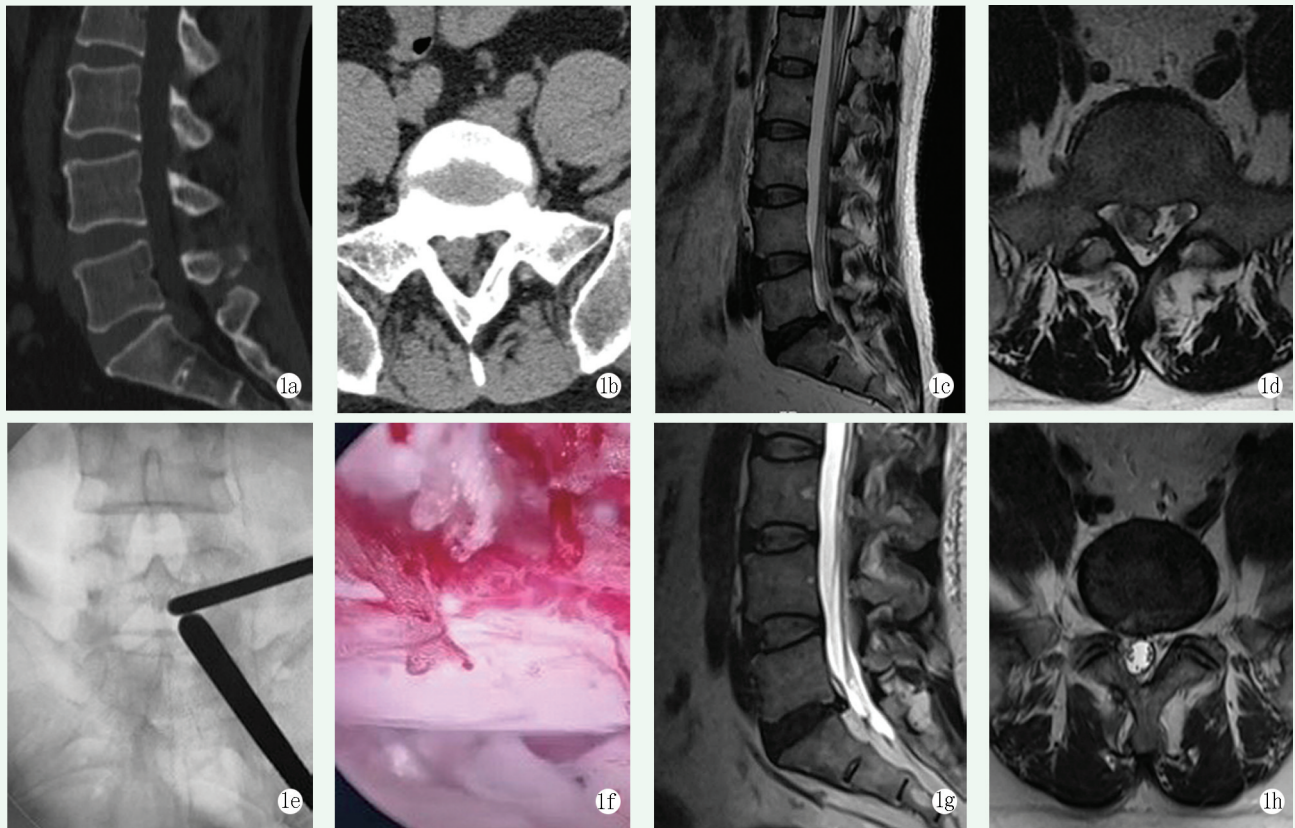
患者,男,48 岁,诊断为 SLDH,手术方式为 UBE。1a, 1b: 术前 CT 提示 L₅S₁ 椎间盘右侧脱垂并向下游离,无明显钙化; 1c, 1d: 术前 MRI 提示 L₅S₁ 右侧脱垂且向下游离的髓核组织侵占椎管,压迫右侧 S₁ 神经根; 1e: 术中透视定位建立操作通道; 1f: 术中切除脱垂的髓核组织后,探查神经根减压充分; 1g, 1h: 术后 3 个月 MRI 显示 L₅S₁ 右侧脱垂且向下游离的髓核组织完全切除,神经根无明显受压,椎管占位率较术前明显下降。
